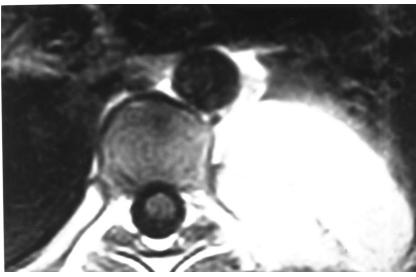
T2-Weighted axial MR image; the lesion shows uniform high signal intensity relative to muscle.
